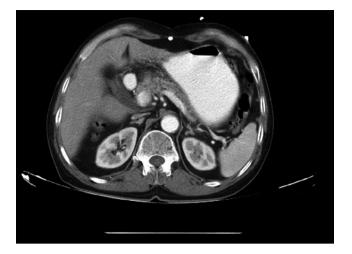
Abdominal CT scan done with IV and oral contrast
